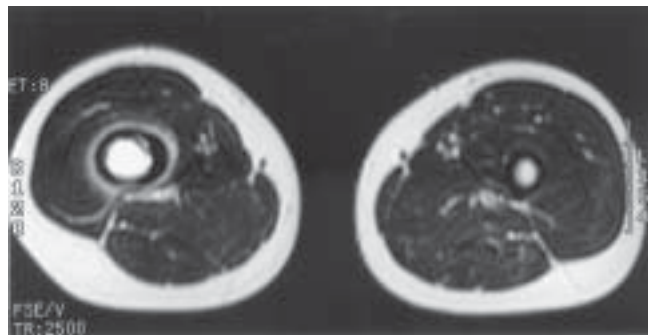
Transverse MRI image of the femur showing the central lesion and a ring of periosteal reaction.
